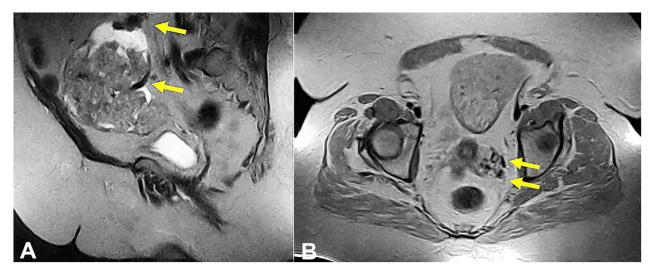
Pelvic MRI - T2 weighed images. A – Sagittal view of a pedunculated right uterine mass with enlarged gonadal artery and vein (arrows); B – Axial view of the dilated left uterine artery and vein with tortuous vessels surrounding cervix (arrows).
